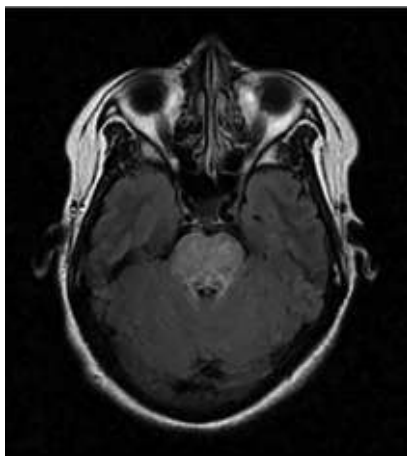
Osmotic demyelination syndrome on MRI. (Adapted with permission from Chang KY, Lee IH, Kim GJ, et al. Plasma exchange successfully treats central pontine myelinolysis after acute hyponatremia from intravenous sodium bicarbonate therapy. *BMC Nephrol.* 2014;15:56. doi:10.1186/1471-2369-15-56.)
